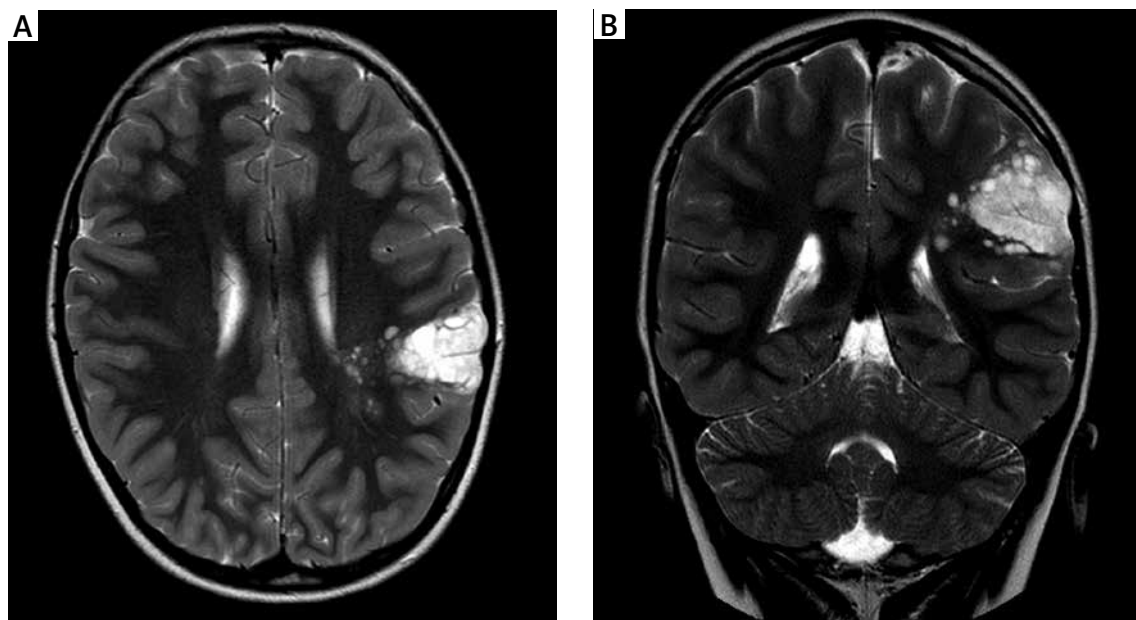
Magnetic resonance images (MRI) of dysembryoplastic neuroepithelial tumour (DNT). A) The multi-nodular intracortical lesion of high signal intensity on axial T2-weighted MR image. B) Coronal T2-weighted MRI with hyperintense cortical abnormality (Courtesy of Professor M. Roszkowski).
